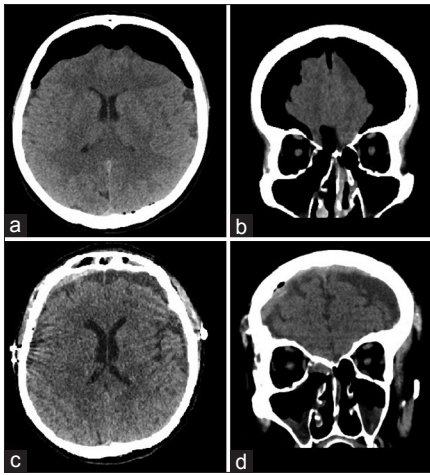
Preoperative computed tomography revealing bifrontal pneumocephalus (a and b). Postoperative computed tomography obtained on the 9th day revealing a complete resolution of the pneumocephalus (c and d)
